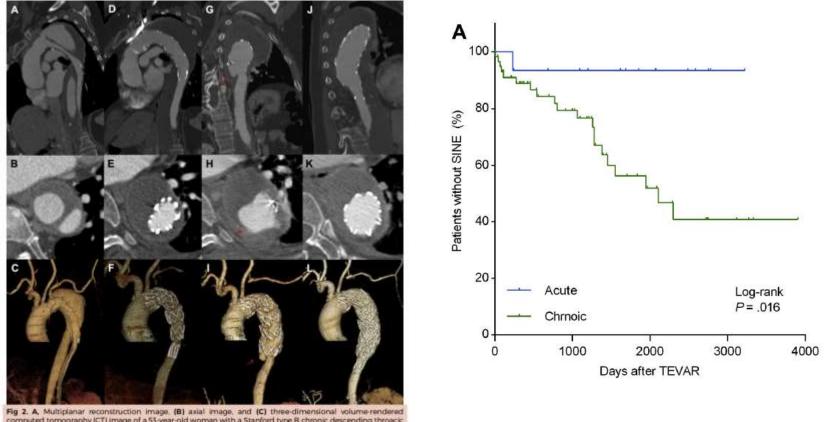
A. Multiplanar reconstruction image. (B) axial image, and (C) three-dimensional volume-rendered computed tomography (CT) image of a 55-year-old woman with a Stanford type B chronic descending threacic aortic dissection. D-F. Thoracic endovascular aortic repair (TEVAR) is performed with a 38 × 150 SEAL stert graft (5&G Biotech Inc, Seorgnam, Korea), and the failse lumen is completely thrombosed. Distal oversizing ratios of the stent graft by maximal diameter, mean diameter, circumference, and area were III%, 16(%), 46(%, and 580%, respectively. G-I, At follow-up 9 months later, small new intimal tear (red arrow) has developed at the distal margin of the stent graft. 3-14, An additional 4-0 × 110 SEAL stent graft is inserted at the distal margin of the original stent graft, and the distal intimal tear is completely regressed.
